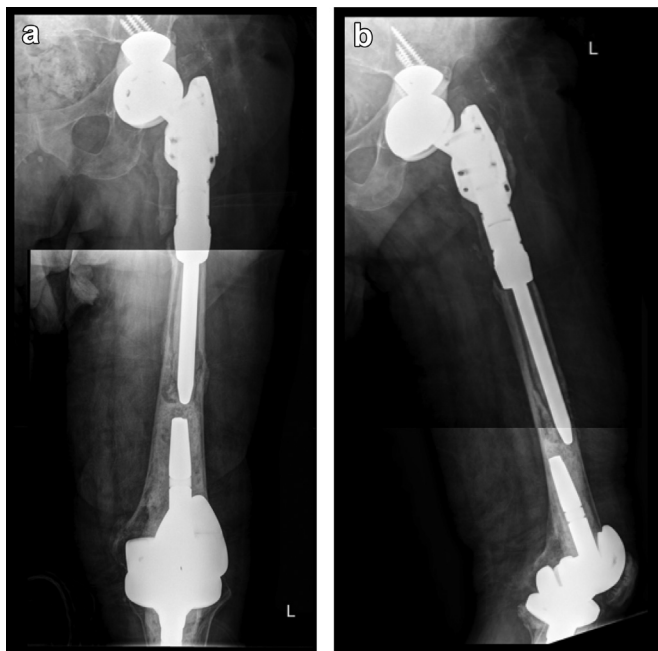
Preoperative anteroposterior (a) and lateral (b) radiographs demonstrating periprosthetic osteolysis and gross loosening.
